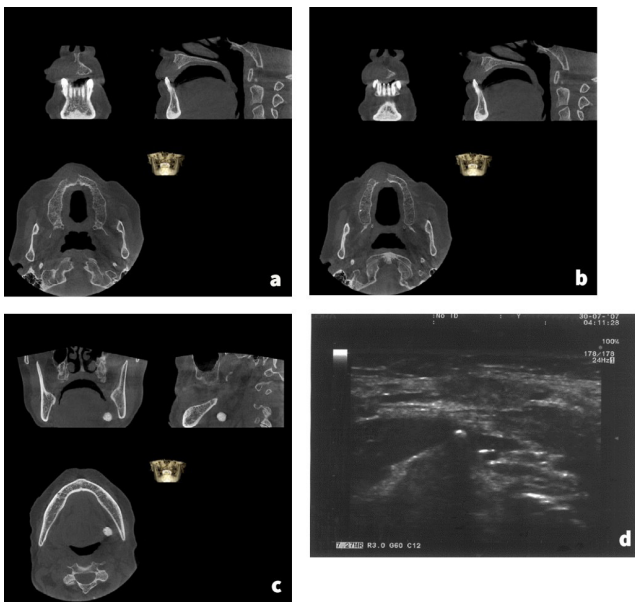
a. CBCT sections of the CGCG. Note the buccal and palatal bone cortex perforation. Corticated and well-defined borders. b. Close relation with the lesion and nasopalatine canal cortex. c. Unilateral left sialolithiasis on the CBCT sections. d. Sialolithiasis on the USG imaging.
